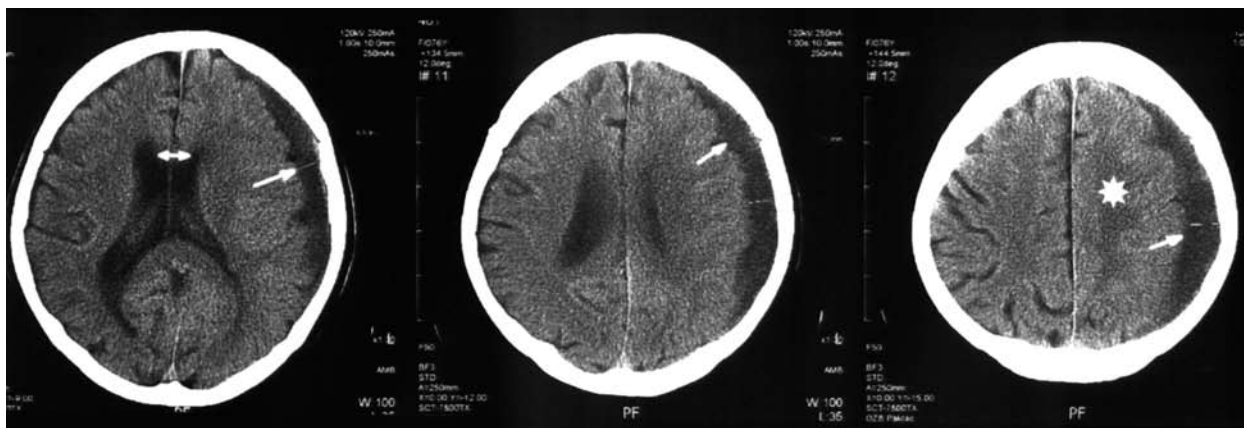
Initial CT scan shows left-sided chronic subdural hematoma (white arrow) with slight shift on the opposite side (double-headed white arrow) and swollen left half of the brain (white star).
